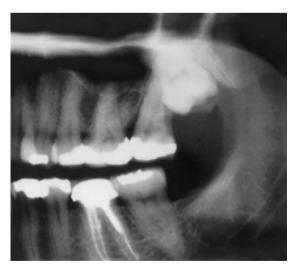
Panoramic radiograph showing the impacted third molar.
